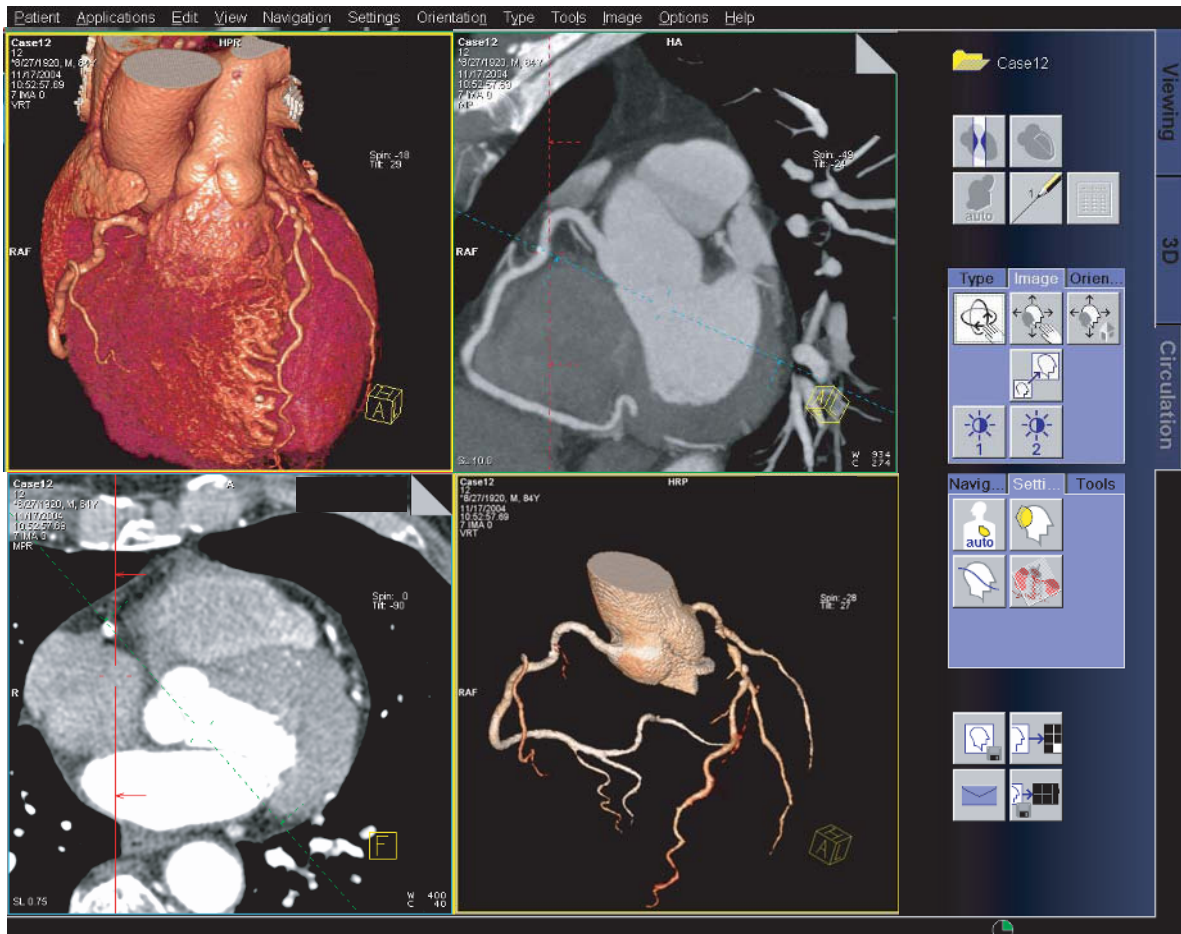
An automated segmentation of the entire coronary artery tree, based on an examination obtained on a 64-slice CT scanner with acquisition of 64×0.6 -mm slices per rotation. Based on the isolated heart with the rib cage removed (*upper left quadrant*), the software detects all coronary segments from a single marker (*lower right quadrant*) that was placed in the aorta just above the origin of the left main coronary arteries. (Case courtesy of Toyohashi Heart Center, Japan)
